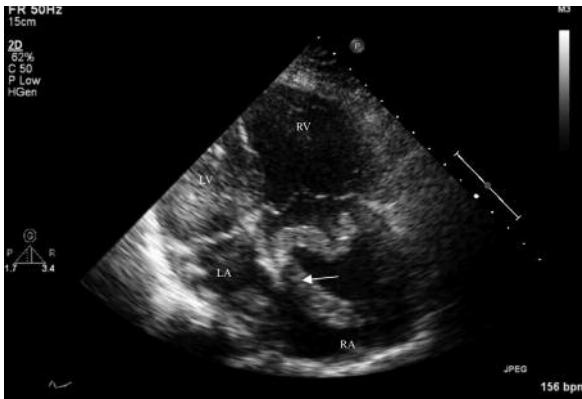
Apical 4 chamber echo view shows giant thrombus in right atrium and thrombus protruding into the right ventricle during the systole. RA: right atrium; RV: right ventricle; LV: left ventricle; LA: left atrium, arrow denotes giant thrombus.
